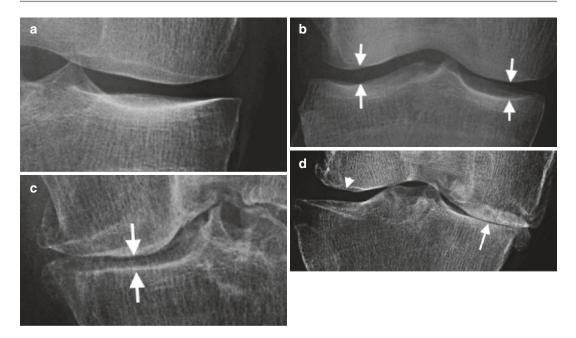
Joint space (*arrows*) loss on radiographs. (a) Mild medial tibiofemoral joint space loss, (b) normal example for reference, (c) moderate to severe, and (d) severe, almost complete, joint space loss medially; note
